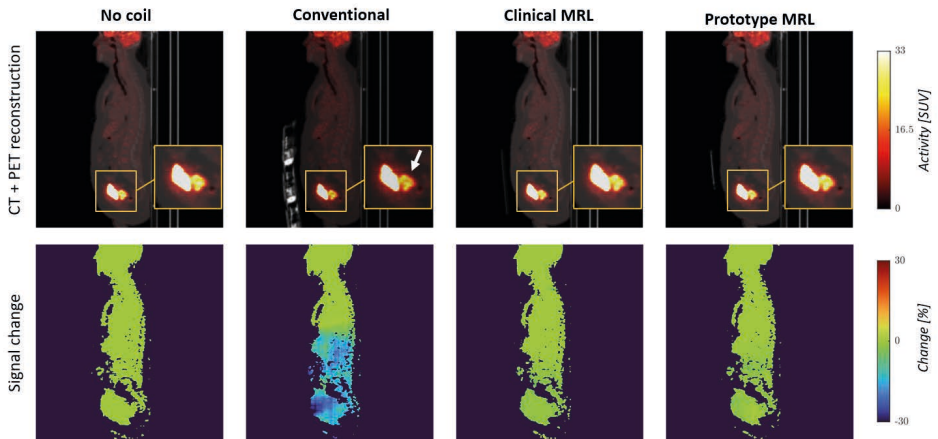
Example of each coil's impact on the PET reconstructions of a representative prostate cancer patient (patient 1). Top row: PET reconstructions displayed on top of the CT with coil. The conventional array visibly reduces the PET signal in the tumor (white arrow), while the signal was similar when the MRL arrays are used. The bright structure to the left of the tumor is the bladder. Bottom row: relative change of the PET signal. Only regions with sufficient PET signal are shown to avoid noise amplification.
